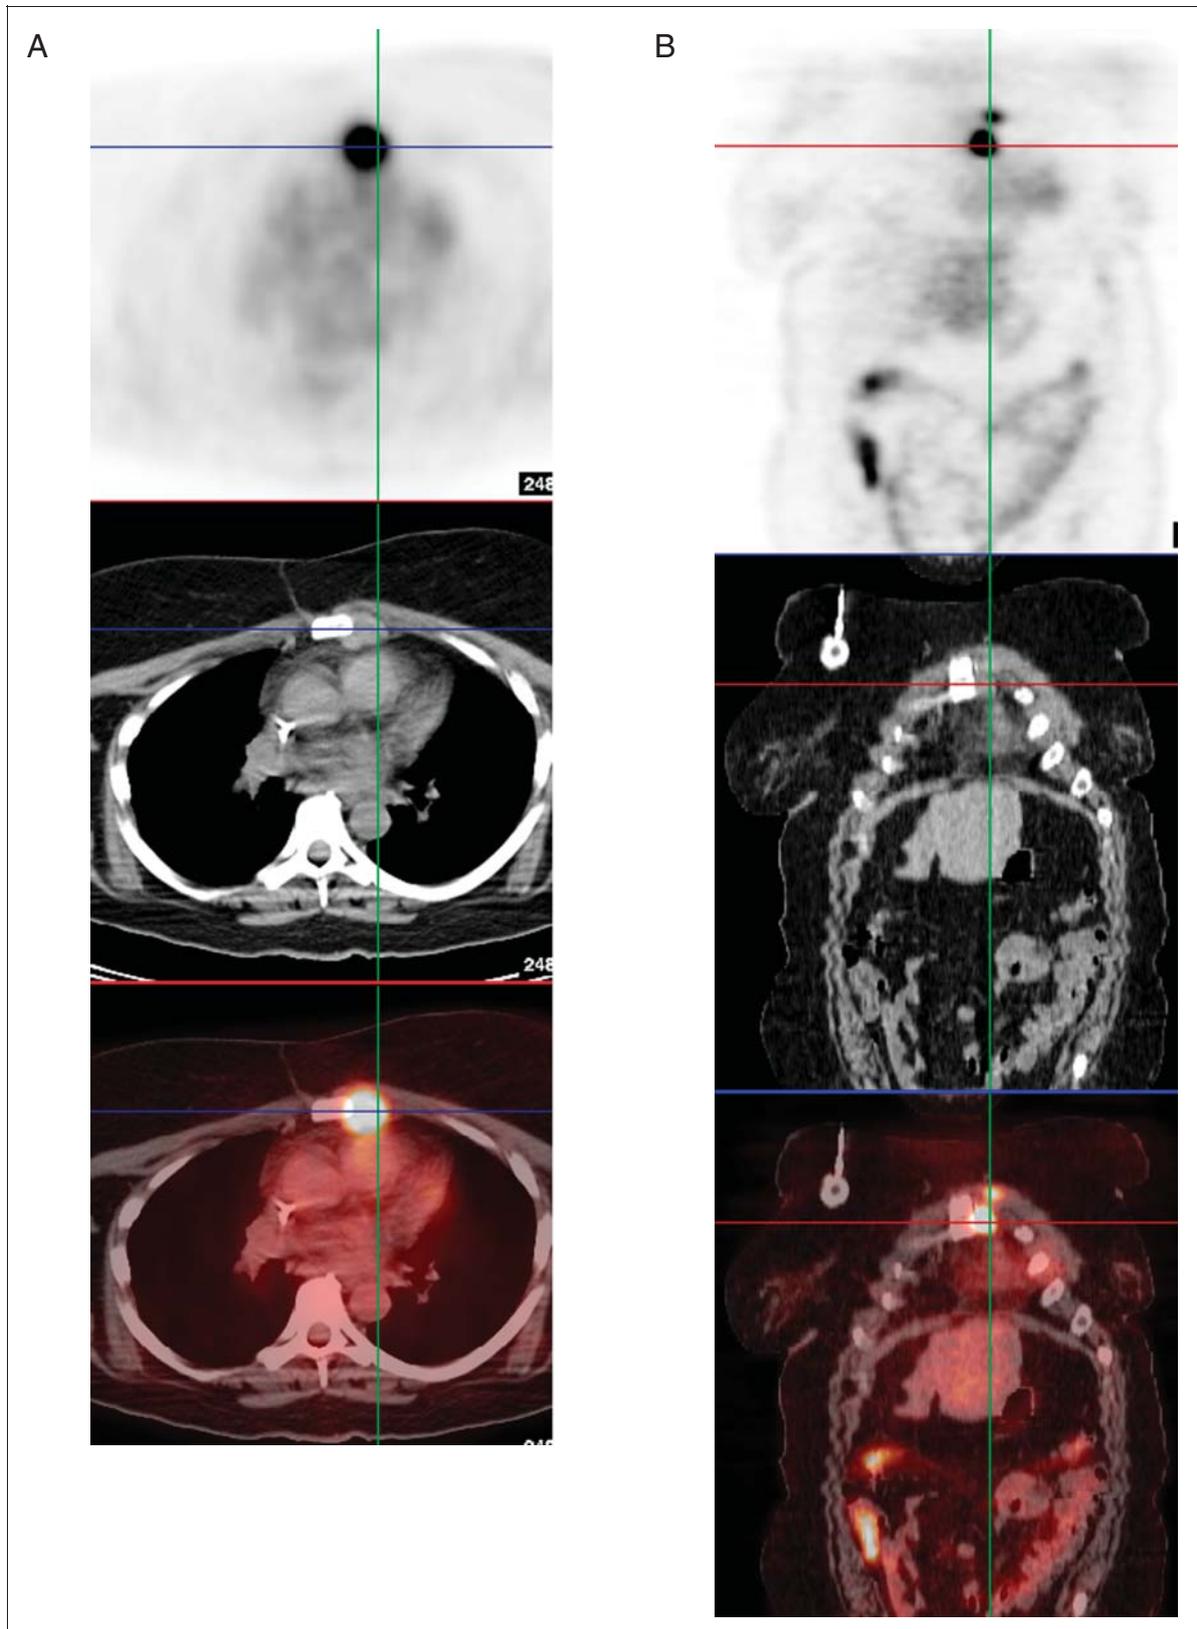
FDG PET/CT detection of internal mammary lymph nodes. (A) Top to bottom: FDG-PET, CT, and fusion PET/CT coregistered transaxial images; (B) top to bottom: FDG-PET, CT, and fusion PET/CT co-registered coronal images.
